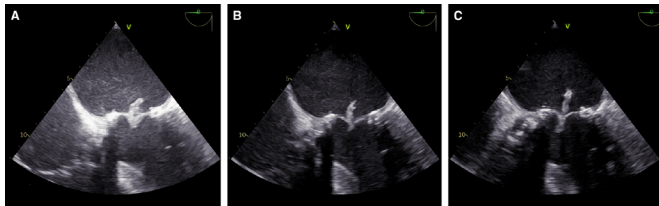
Mid-oesophageal transoesophageal views demonstrating a large vegetation attached to the prosthetic mitral valve. (A) Findings at presentation, revealing a 29 mm long mobile vegetation on the posterior valve leaflet. There was only trace regurgitation and no obstruction of transmitral flow. No definitive evidence was found of paravalvular pathology or involvement of the aortic prosthetic valve, pacemaker leads or right-sided valves. (B) Findings at presentation to the university hospital, after 6 weeks of antibiotic treatment. A large vegetation of the mitral bioprosthesis and trace regurgitation was confirmed. There was an increased transvalvular diastolic gradient of 9 mm Hg. No evidence of prosthesis dehiscence or other signs of paravalvular infection were found. (C) Findings the day before surgery, revealing a more mobile and irregular vegetation, and apparent thickening of the posterior leaflet compared with previous examinations.
